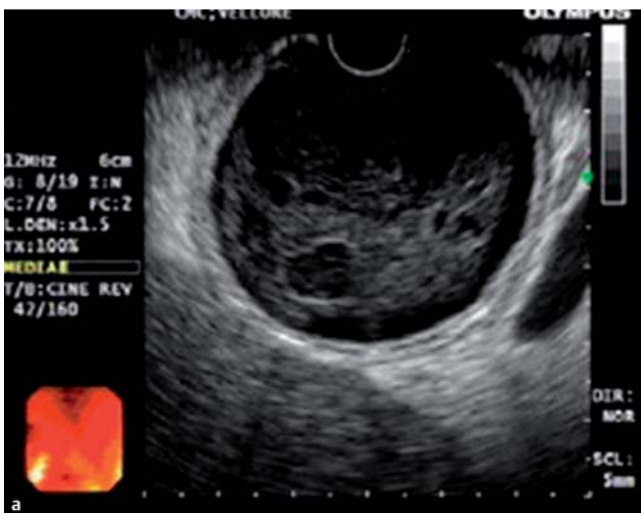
Radial and linear endoscopic ultrasound (EUS) images showing a cystic lesion in the second part of duodenum containing heterogeneous material, with a layered appearance suggestive of bowel wall.
